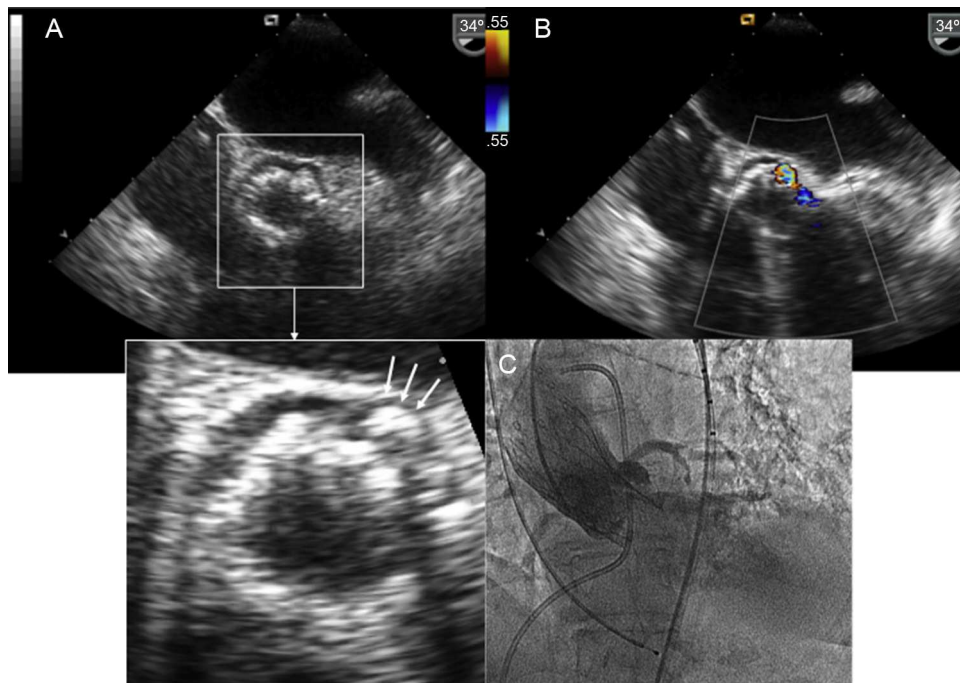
A: Calcific protuberance (arrows) preventing coaptation of a Corevalve prosthesis to the periprosthetic tissue. B and C: Periprosthetic aortic regurgitation (despite correct position), shown on color Doppler (B) and angiography (C).
